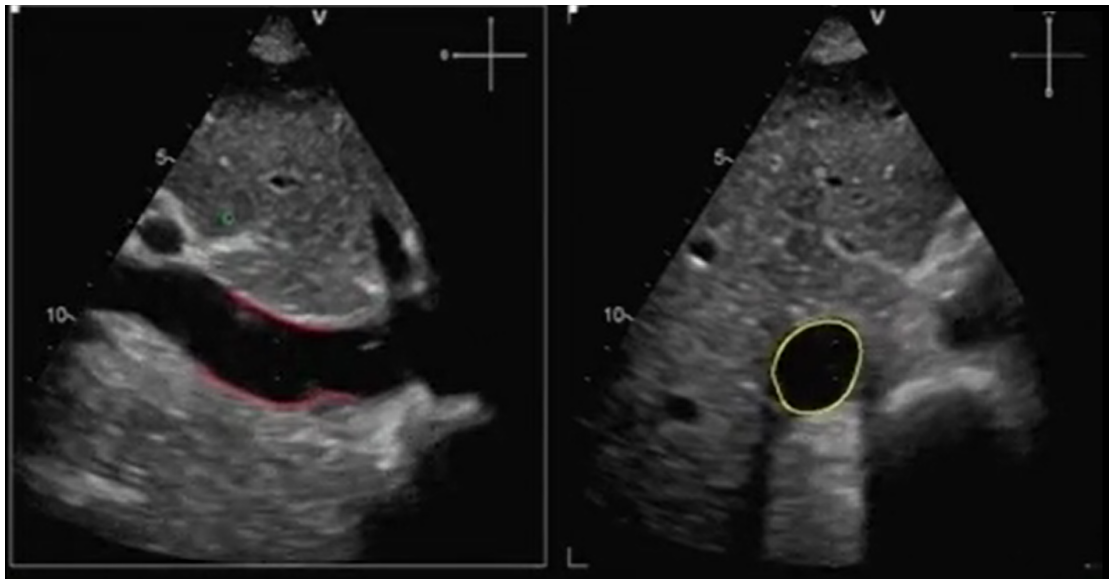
Example of a frame of the ultrasound videoclip in which the IVC is correctly segmented by the algorithm along both the longitudinal axis (left) and transverse axis (right). On the left image the edges of the IVC are indicated in red, on the right image the edges of the IVC are indicated in yellow [3].*
